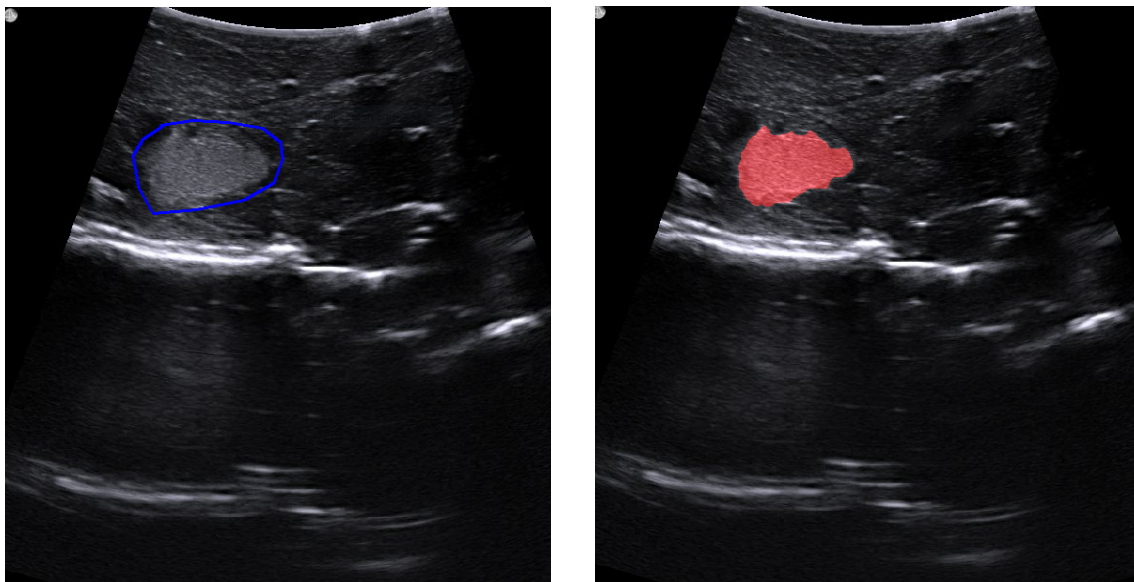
Ultrasound image after closing holes.
